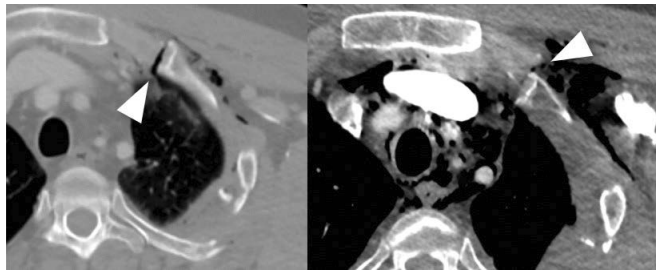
43-year-old male, motor cycle accident. Axial CT images on arrival (left) and on day 3 (right) show that the left sided first rib costal cartilage fracture (arrowhead) has dislocated over time. Also, the amount of free air (emphysema) in the mediastinal fat and soft tissues below the pectoralis muscles has increased.
